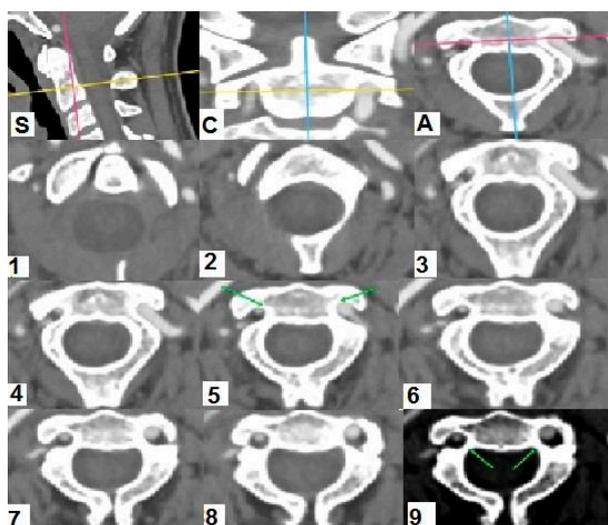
0.5mm 3D-CTA sections taken along the axis pedicle direction. S: Sagittal image, C: Coronal image, A: Axial image. Numbered photographs are 0.5mm axial sections parallel to the pedicle. The arrows in image 5 indicate the peak of VAG and then the parameter 'e' is calculated according to the number of slices. The parameter 'a' can be measured in slice 9 ofm Fig.1, where the markings indicate the distance from the entrance of the VAG to the vertebral canal.
